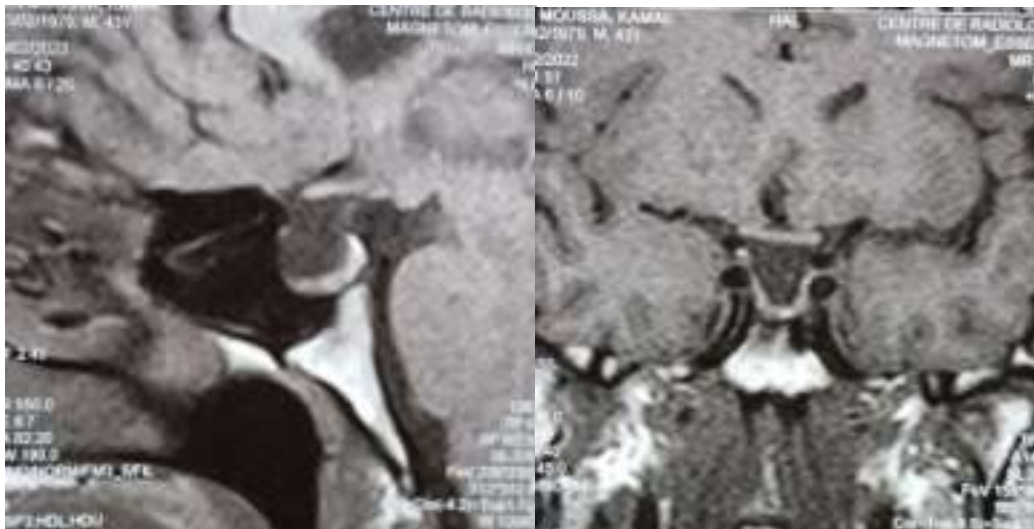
MRI images showing a partial empty sella with a laminated pituitary gland.
